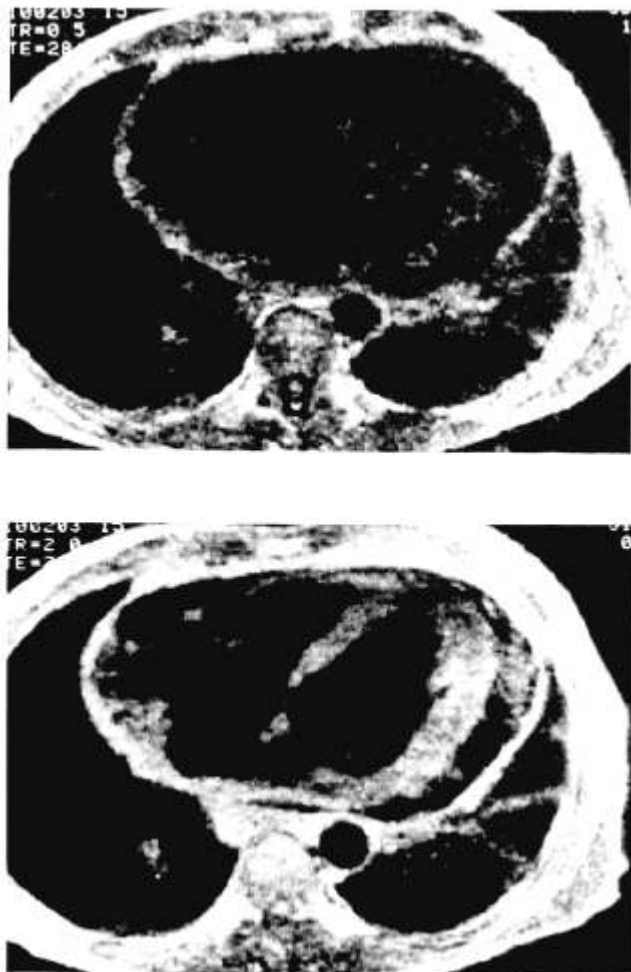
Gated magnetic resonance imaging. Shown are ungated (above) and gated (below) magnetic resonance images in a patient with chronic pericarditis, pleuritis, and pericardial effusion. Little of the cardiac anatomy can be seen in the ungated image, but with gating, all of the pertinent anatomy becomes evident. Note particularly the high intensity material in the pericardial sac, which may be evidence of exudate, and the linear streaks related to probable pericardial and pleural adhesions. The pleura is also thickened. (Reproduced from Lanzer P, Ortendahl DA, Botvinick EH, Higgins CB: Cardiac imaging by magnetic resonance, *Cardiac Imaging and Image Processing*. Edited by Collins, Steve M. and Skorton, David J., New York, McGraw-Hill Book Co., 1986, with permission).
